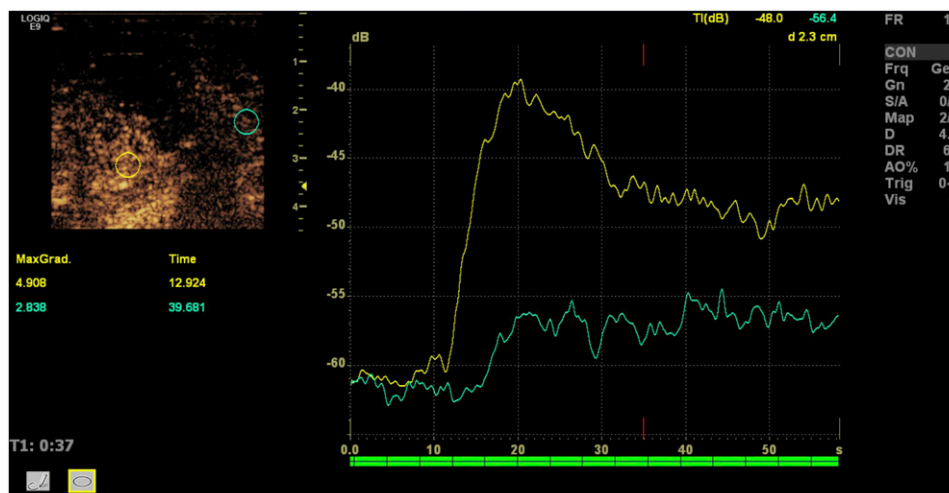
Contrast-enhanced ultrasound of a malignant breast tumor. Yellow curve represents dynamic contrast enhancement in the tumor and green curve represents adjacent normal breast tissue (dB/sec).
